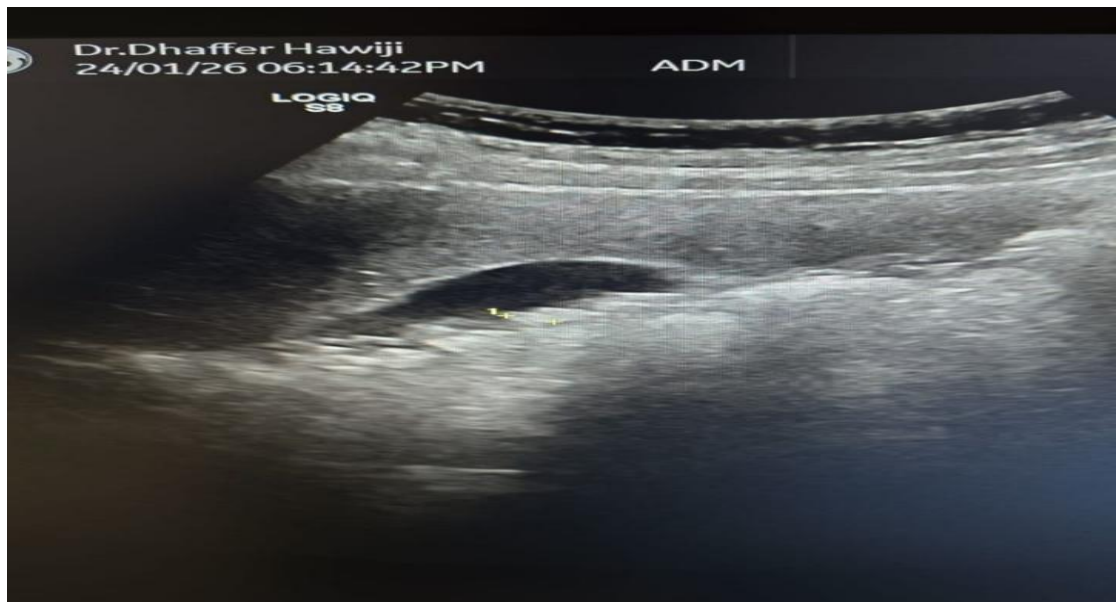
Longitudinal gray-scale ultrasonographic image demonstrating an echogenic gallstone casting posterior acoustic shadowing.
